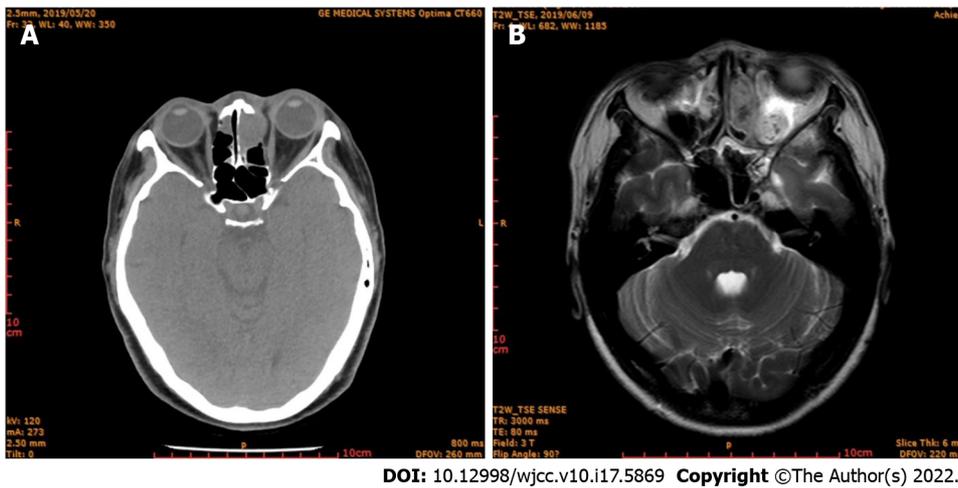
Imaging examination. A: Computerized tomography examination showing tumor invasion of the ethmoid sinus; B: Magnetic resonance imaging showing a mass in the ethmoid sinus.
